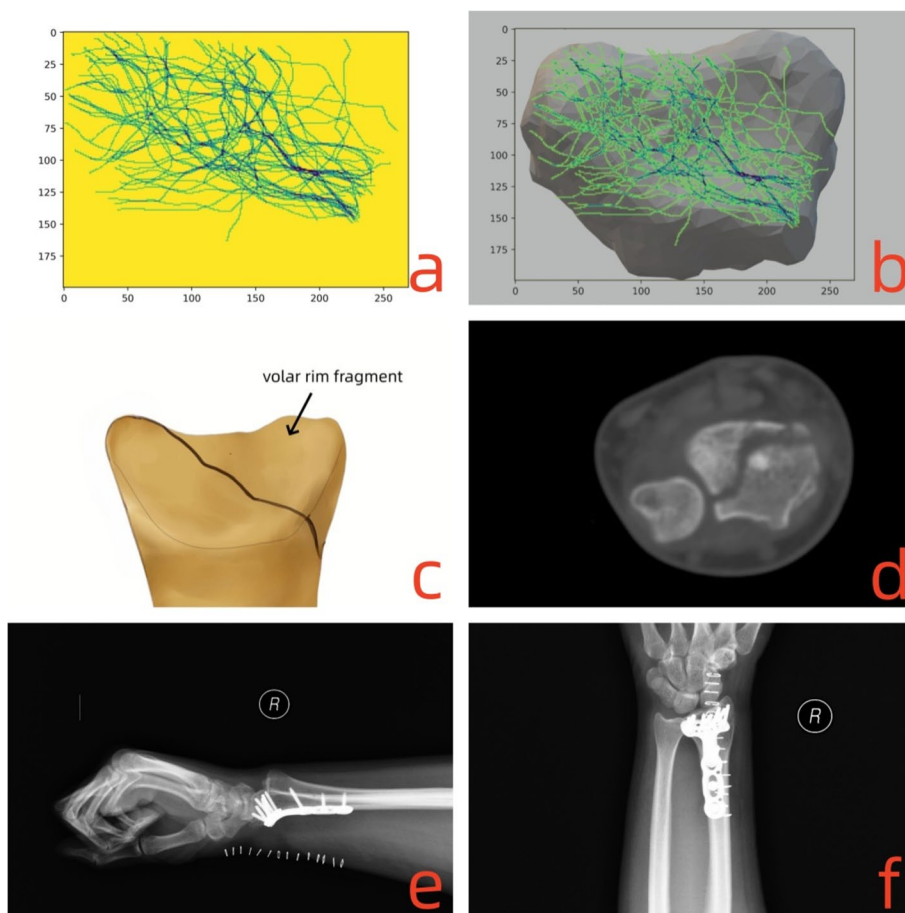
For type 1.1 DRFs, the fracture line traversed from the the sigmoid notch to the volar side articular surface. The morphological characteristics and the clinical treatment were shown as follows: a)-b) the fracture lines clustered by and covered on the intra-articular surface; c) the model for type 1.1 DRFs; d) the CT scan for the fracture lines at the articular surface; e)-f) postoperative posteroanterior and lateral X-ray images
